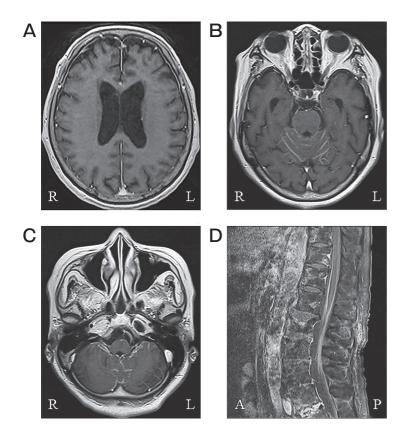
Gadolinium-enhanced T1-weighted MRI showing diffuse leptomeningeal contrast enhancement following the cortical surface of the cerebrum (A), the cerebellar folia (B), the ventral surface of the brainstem (C), and linear or nodular enhancement along the surface of the spinal cord and cauda equina (D).
